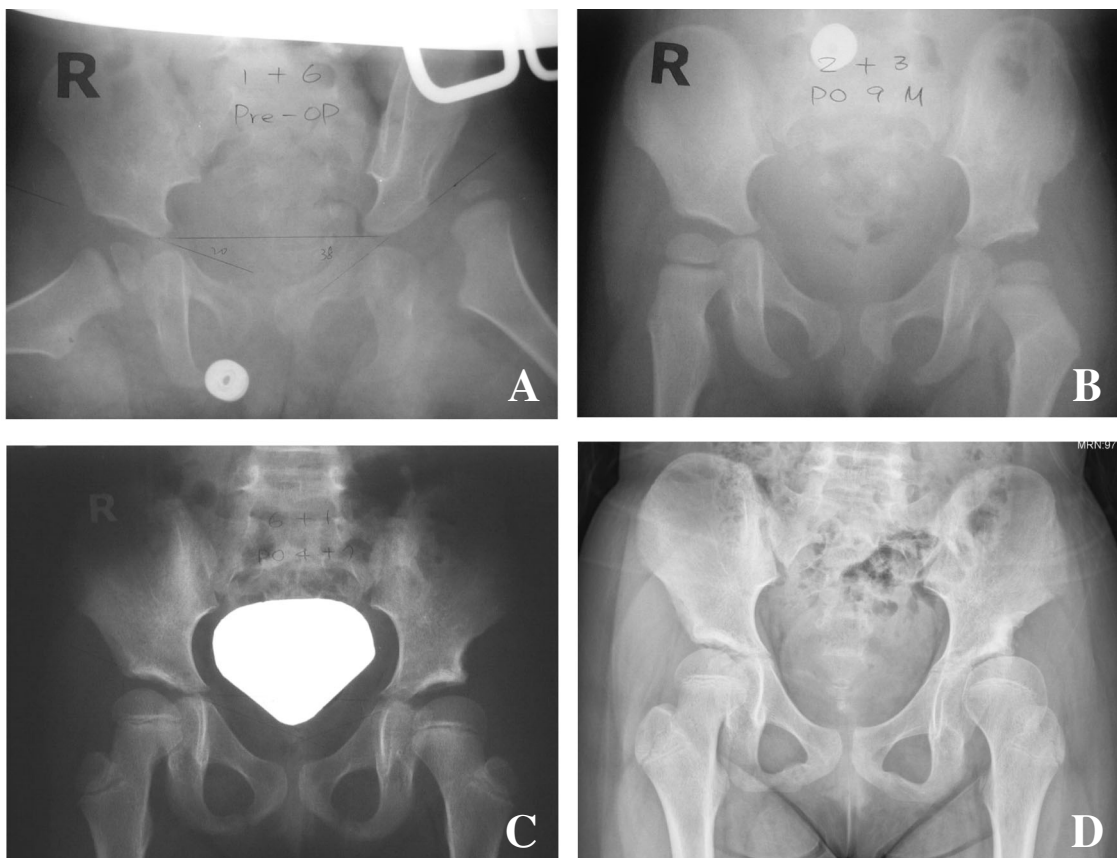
(A) A girl aged 1 year, 6 months with left hip redislocation after closed reduction and casting. (B) Nine months after open reduction and Salter's osteotomy, there is no evidence of osteonecrosis. (C) Radiography at age 6 years (4.5 years after operation) shows mild coxa valga of the left hip. (D) Radiography at age 11 years shows hip dysplasia from an initially successful operation (Severin class III).
